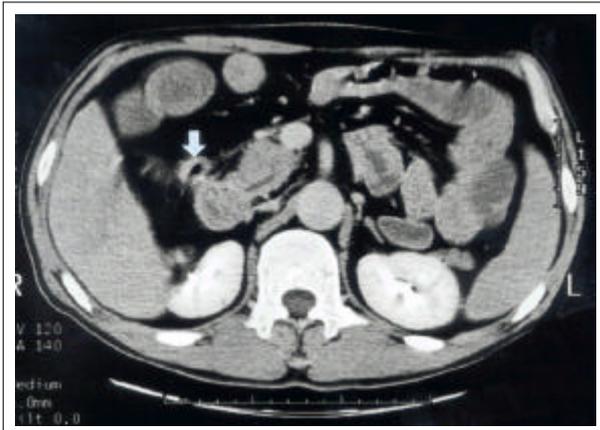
Abdominal CT scan shows obstructive mass in hepatic flexure and fistula tract communicating with duodenum (thin arrow).
